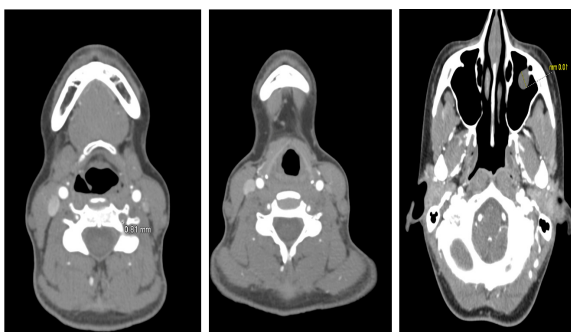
CT Angiogram of head and neck showing bilateral vertebral artery stenosis suggestive of dissection.
